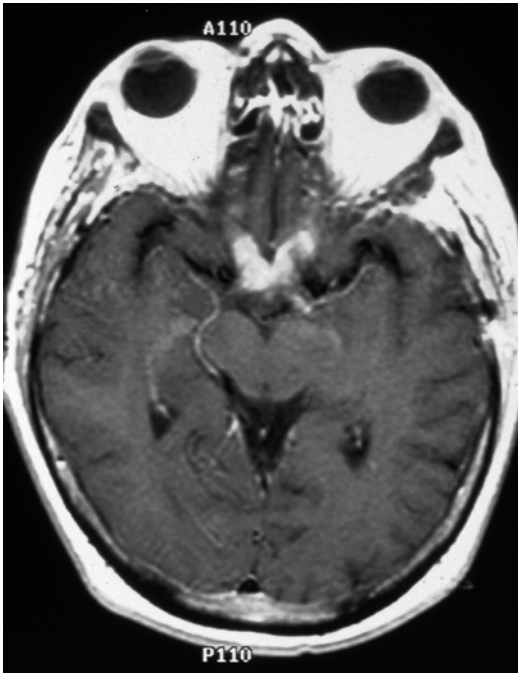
Optic nerve glioblastoma. Contrast-enhanced T₁-weighted axial magnetic resonance imaging (MRI) of the brain showing enhancement of the optic nerves and chiasm (From Cummings [171], Figure 8.9, Page 162. With kind permission of Springer Science + Business Media)
